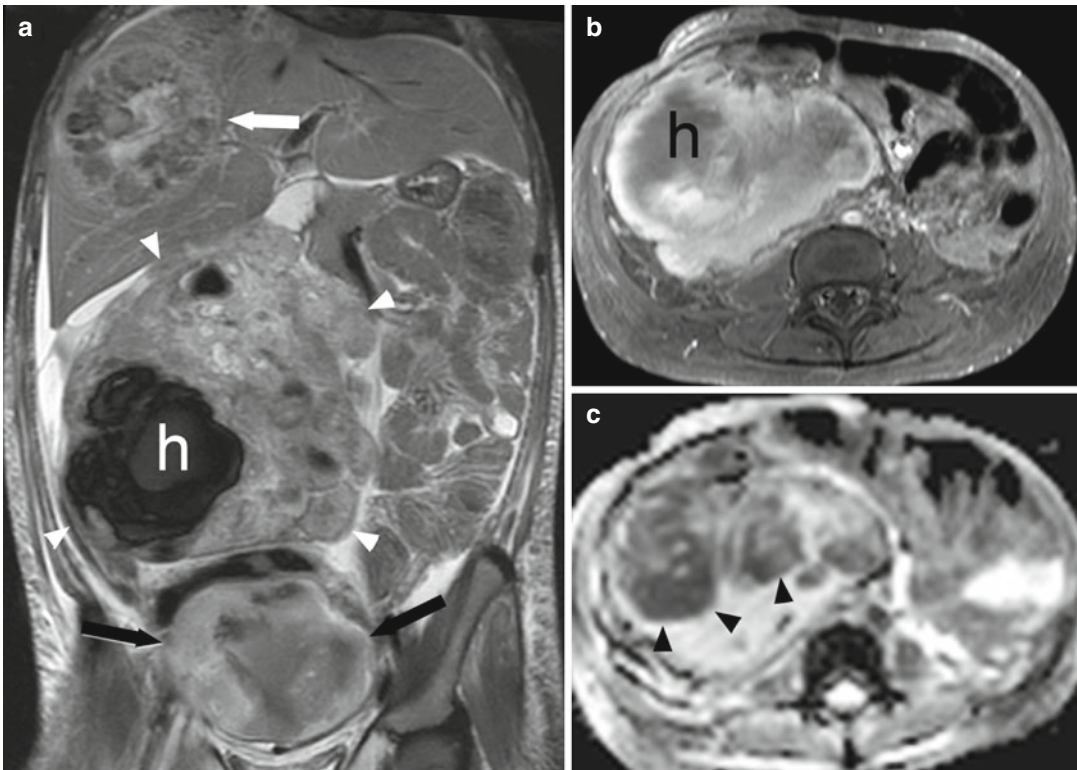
A 6-year-old with Wilms tumor. (a) Coronal fat-suppressed T2-weighted MR image demonstrates the large mass (*white arrowheads*) with central hemorrhage (h). A large metastatic deposit is seen in the right lobe of the liver (*white arrow*) and in the pelvis (*black arrows*). (b) Post-contrast fat-suppressed T1-weighted image confirms
